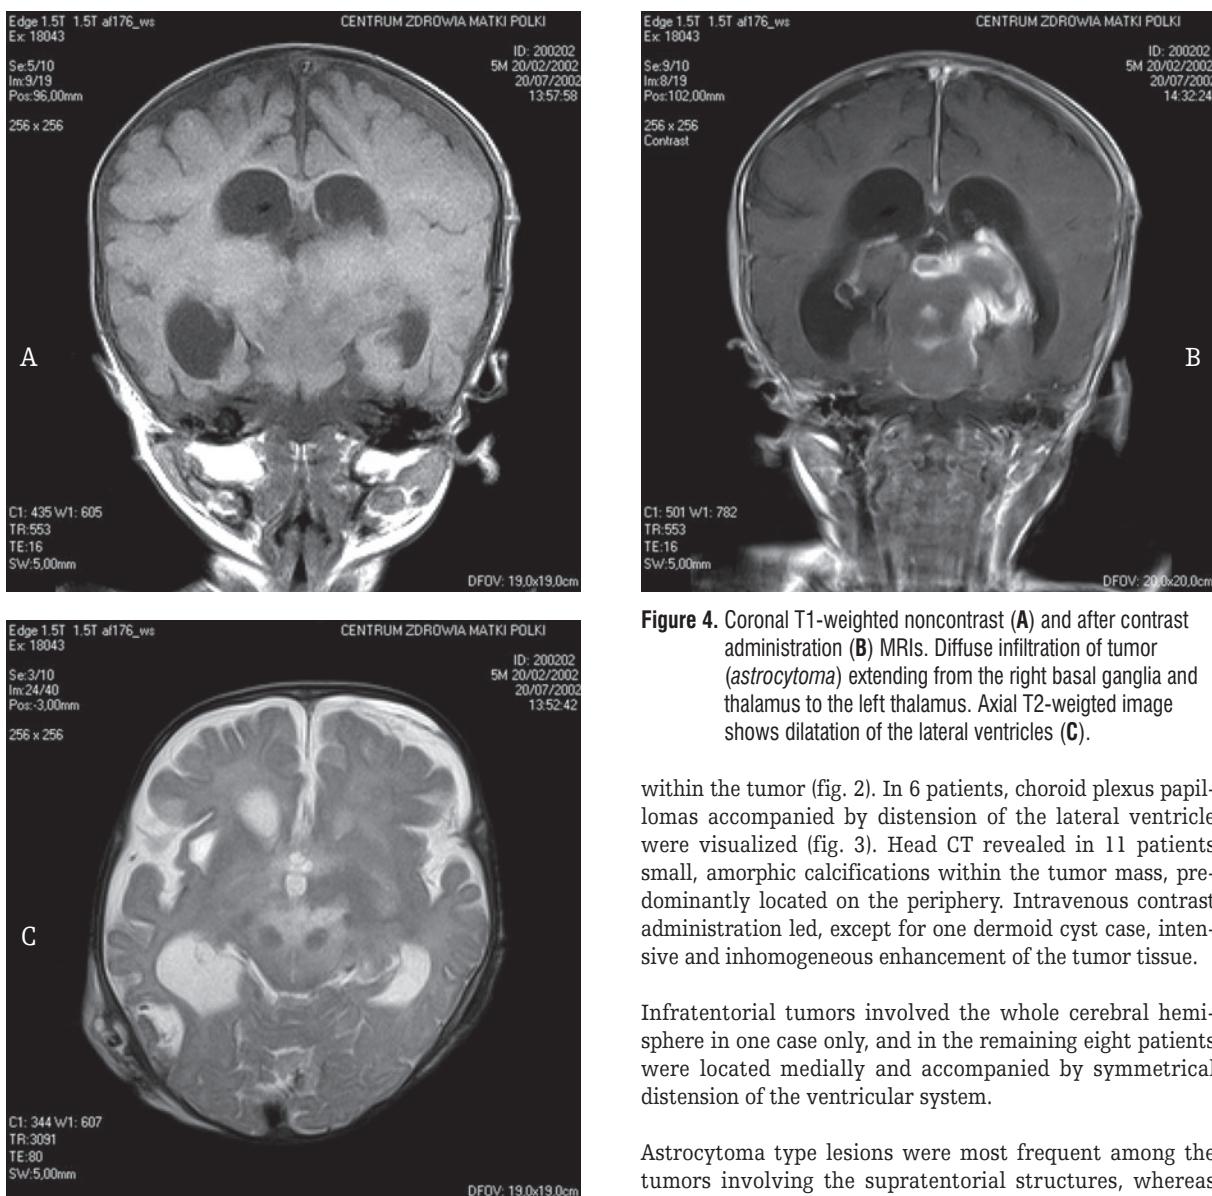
Coronal T1-weighted noncontrast (A) and after contrast administration (B) MRIs. Diffuse infiltration of tumor (astrocytoma) extending from the right basal ganglia and thalamus to the left thalamus. Axial T2-weighted image shows dilatation of the lateral ventricles (C).
